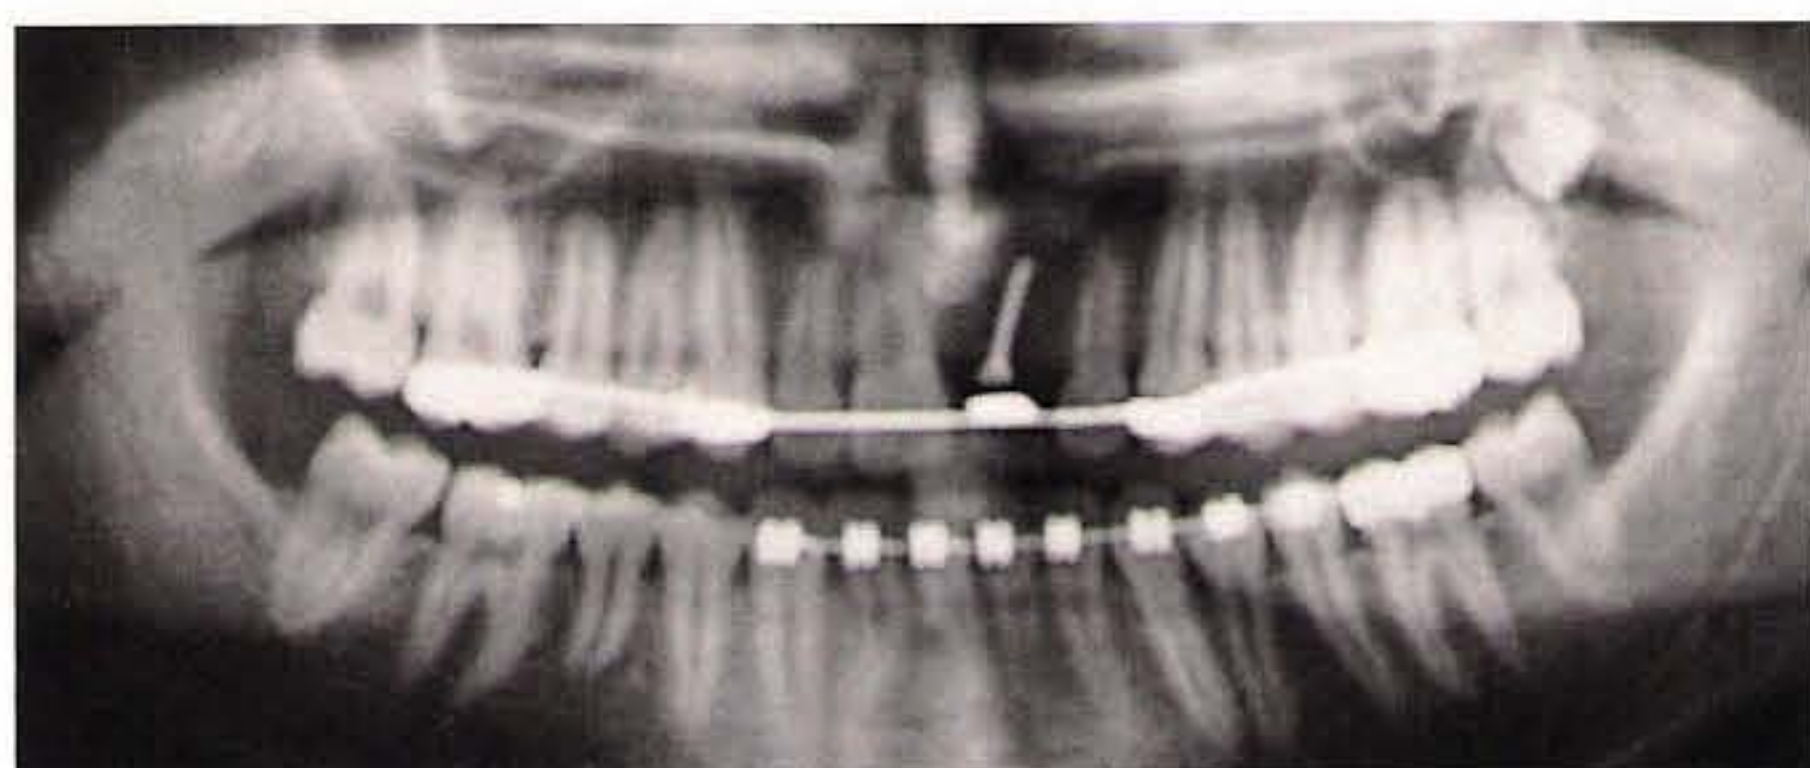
The panoramic radiograph reveals healing of the graft after 6 months.
